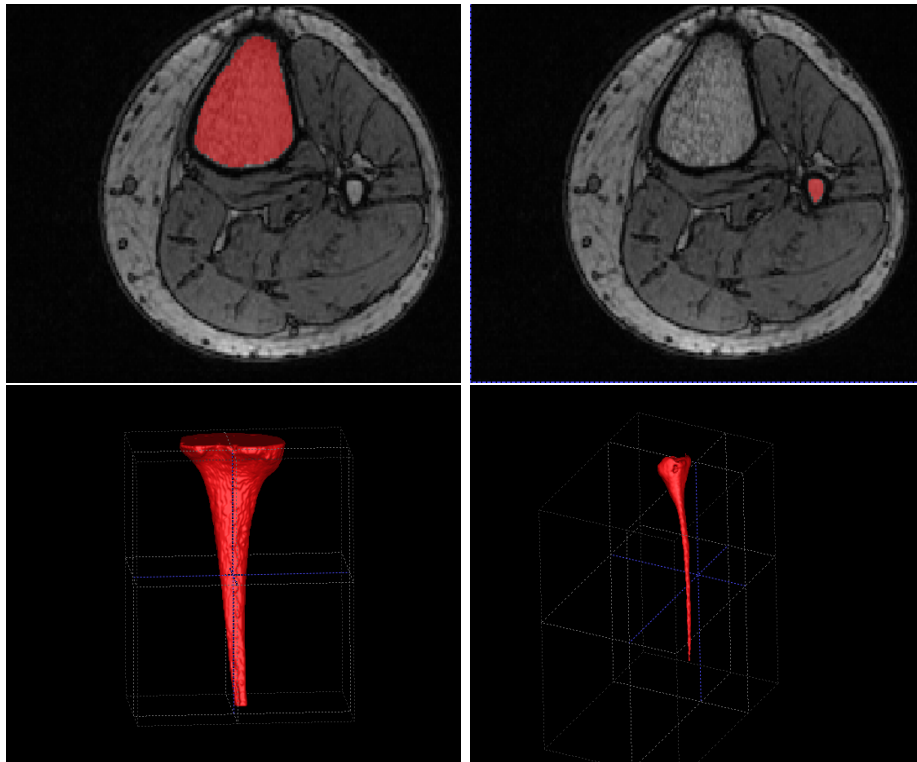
Segmentation of tibia and fibula on T1 weighted MRI are shown (in red) in 2D axial slices and 3D volume. Left column shows tibia, right column shows fibula.
